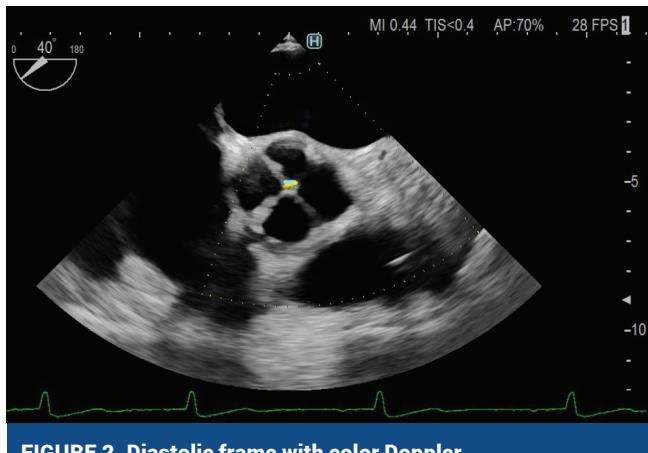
Diastolic frame with color Doppler.
